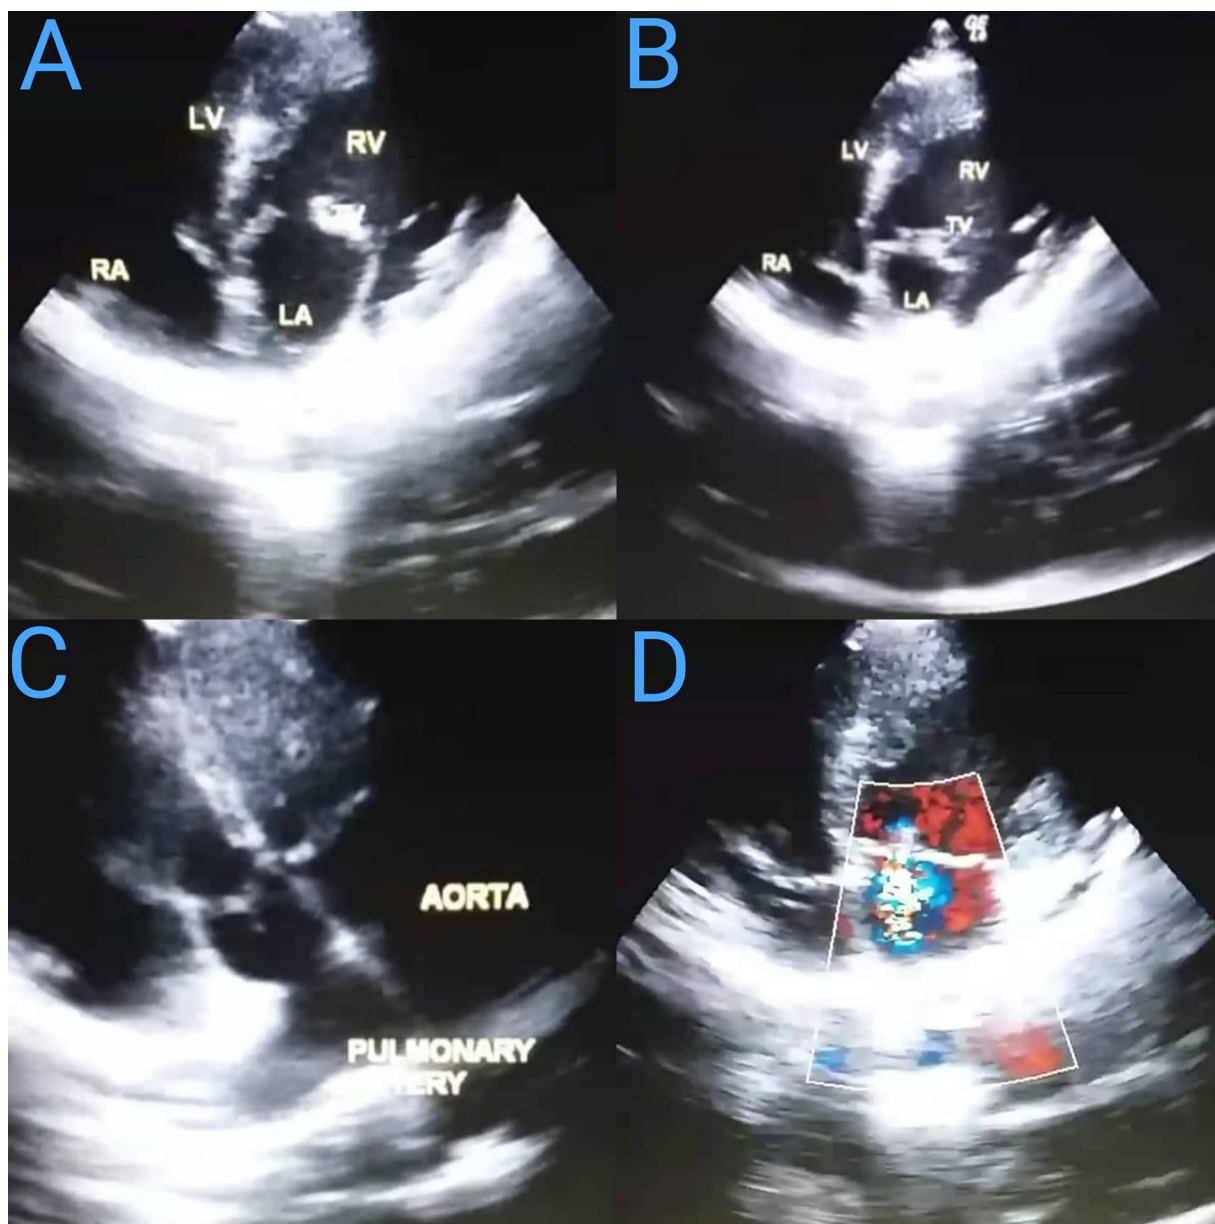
The echocardiogram (A and B) of the apical 4-chamber view reveals atrioventricular discordance with the tricuspid valve being slightly closer to the apex. (C) The parasternal long-axis view (Off-axis) reveals the great arteries in parallel orientation, with the aorta positioned anteriorly and the pulmonary arteries posteriorly. (D) The apical 4-chamber view reveals moderate tricuspid regurgitation. The echocardiogram reveals atrioventricular and ventriculoarterial discordances, along with moderate tricuspid regurgitation, with no other anomalies detected.
